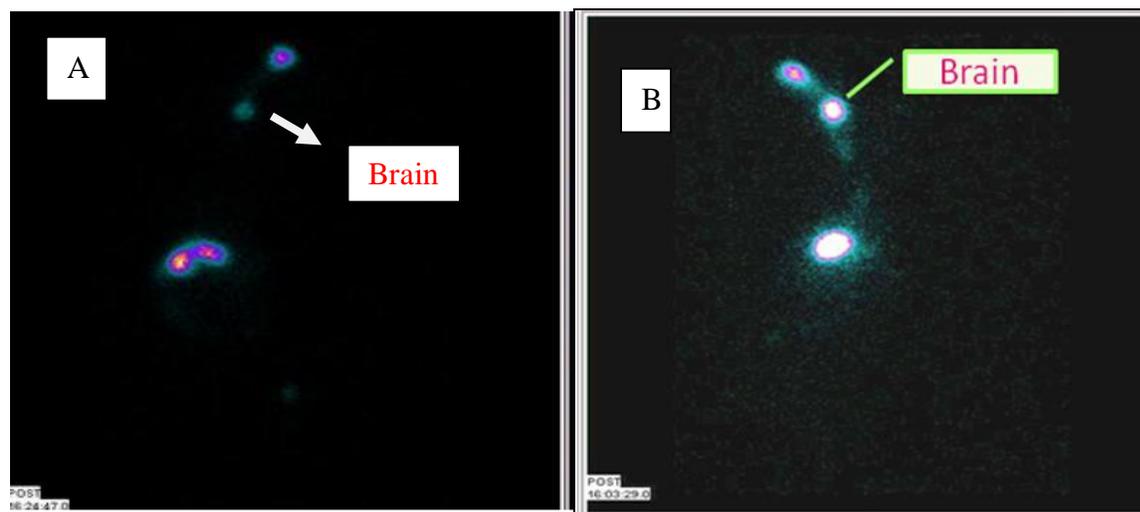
Gamma scintigraphs of ^{99m}Tc labeled A) F-S B) S-SLNs 1 h Post IN administration
